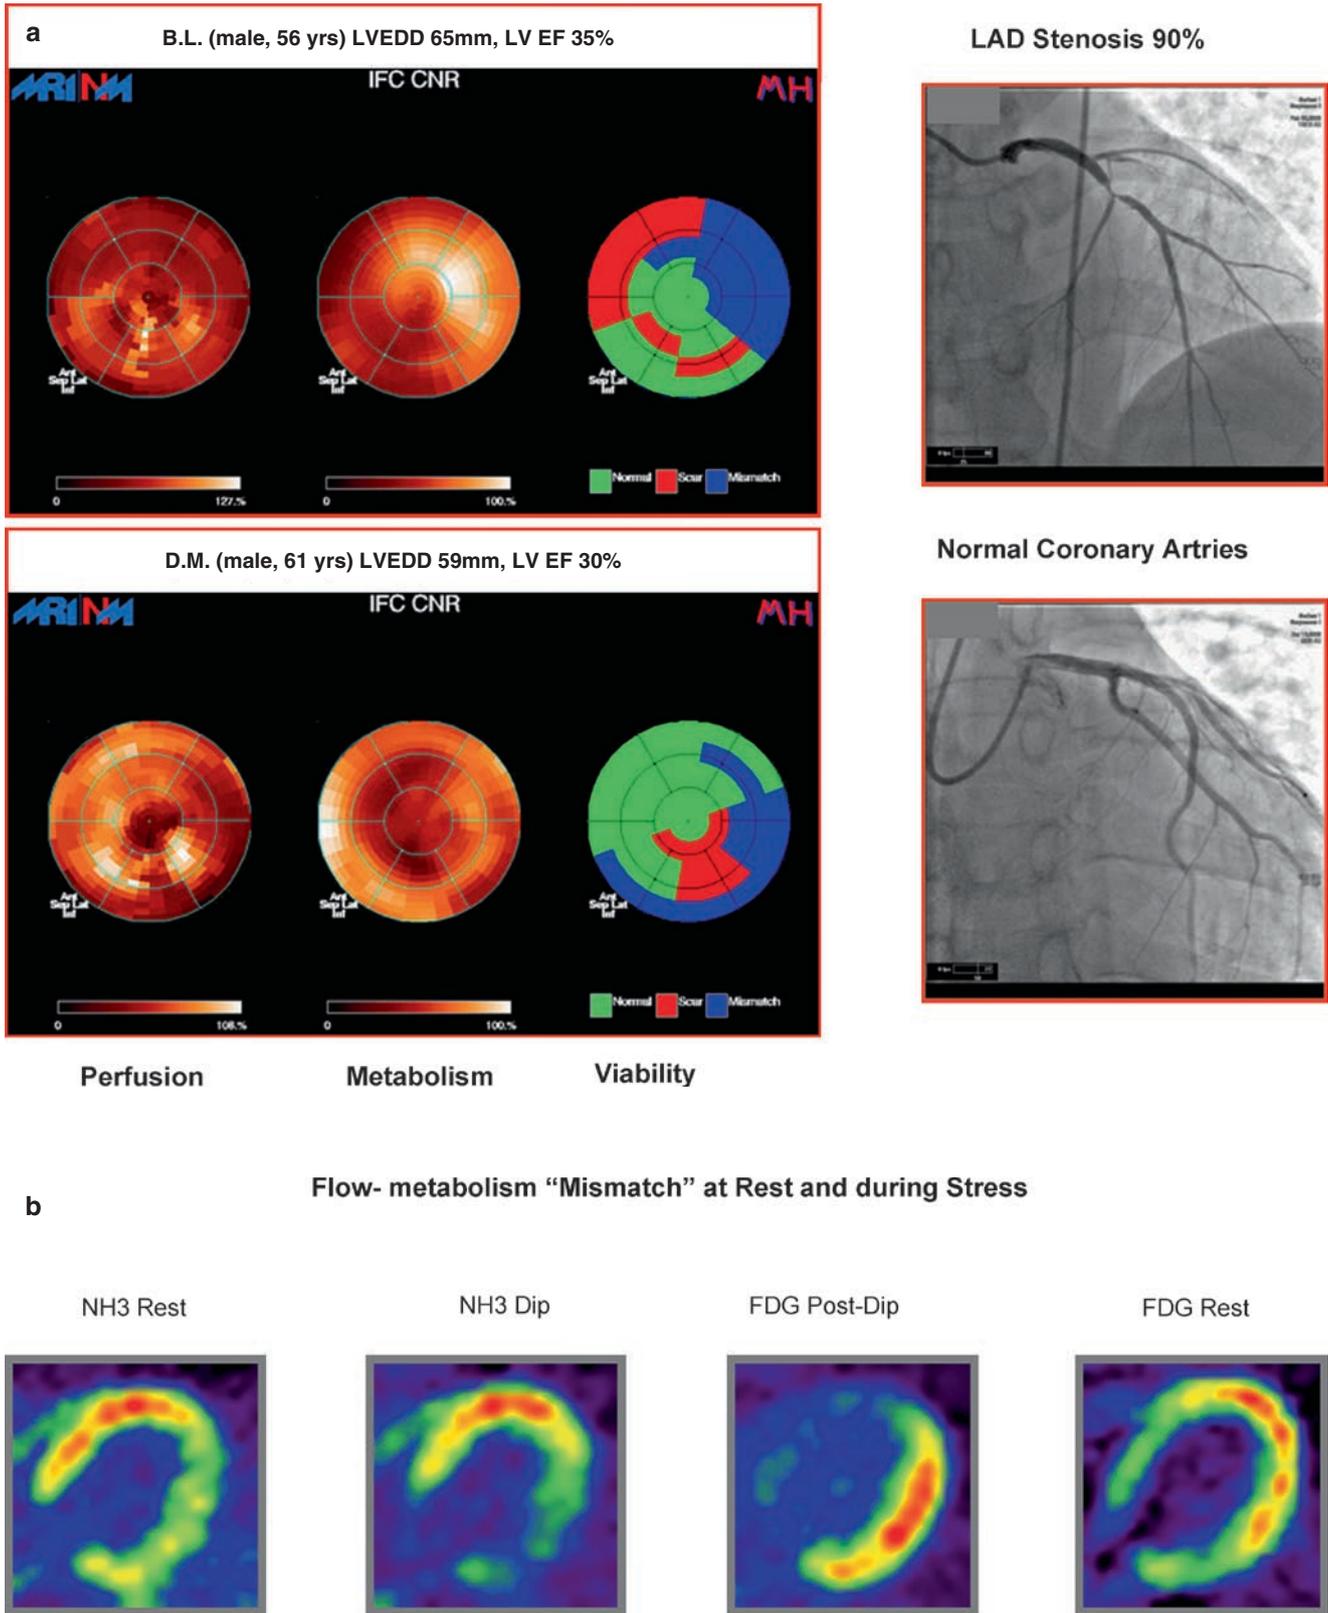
Flow-metabolism regional "match" and "mismatch" patterns typically observed by $^{13}\text{N-NH}_3$ and $^{18}\text{F-FDG}$ PET study in patients with LV dysfunction due to CAD (Fig. 24.8 part a, upper panel) can be frequently observed also in patients with DCM (Fig. 24.8 part a, lower
